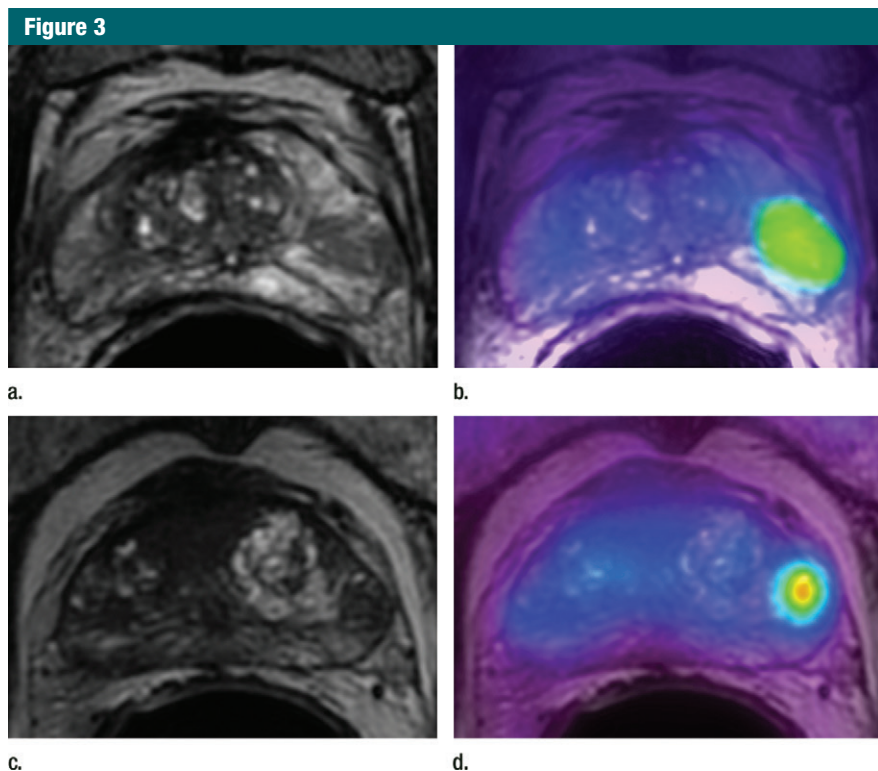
Transaxial PET/MR images in a 58-year-old man with left PCa (Gleason score, 4+3 = 7; pathologic stage III; pathologic EPE involving left posterolateral capsule) show (a) a low-signal-intensity tumor on T2-weighted image with an EPE (PI-RADS score, 5), but (b) T2-weighted PET fused image only shows moderate focal FCH uptake of SUV_{max} of 7.20 (<8.5). PET/MR transaxial images in a 60-year-old man with left PCa (Gleason score, 4+3 = 7; pathologic stage III; pathologic EPE involving left posterolateral capsule) show (c) a low-signal-intensity tumor on T2-weighted image without a definite EPE (PI-RADS score, 4), but (d) high focal FCH uptake of SUV_{max} of 9.6 (>8.5) on T2-weighted PET fused image.
